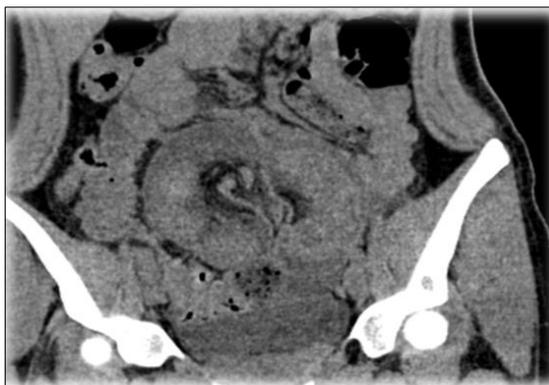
Abdominal CT scan in axial and coronal sections without and with gadolinium injection
